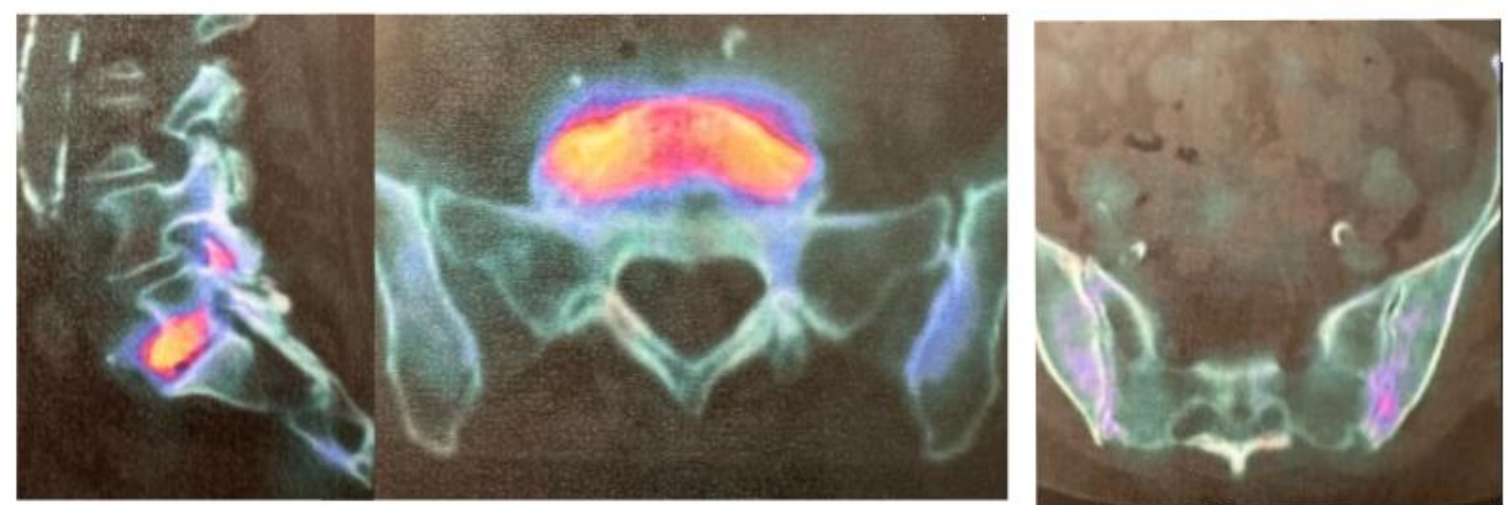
Single photon emission computed tomography with computed tomography findings demonstrate increased radiotracer uptake in the L5 to S1 disc. The L5 to S1 disc was determined to be the dominant pain generator, resulting in a discogenic pain pattern.
